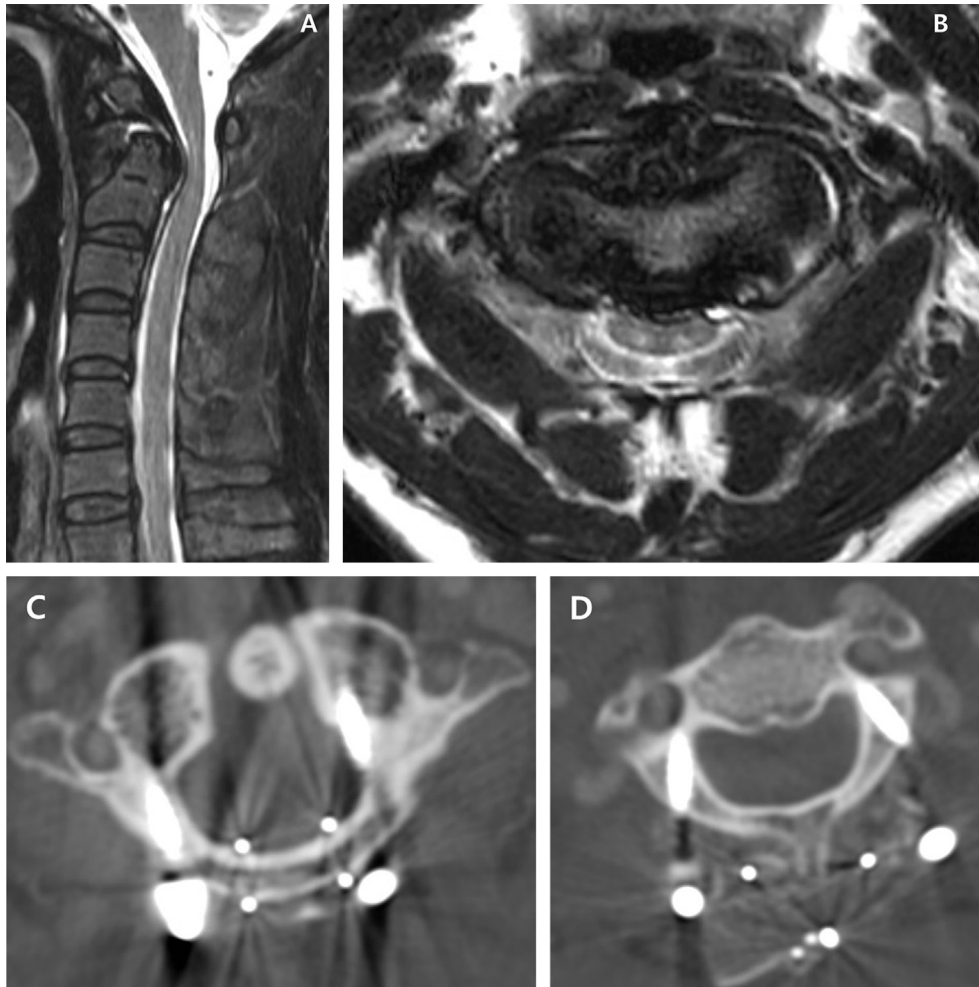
Sagittal (A) and axial (B) MR images showing nonunion of the odontoid process fracture and spinal cord compression by the vertebral body due to chronic C1-2 instability. Spinal cord signal change indicates acute spinal cord injury.
